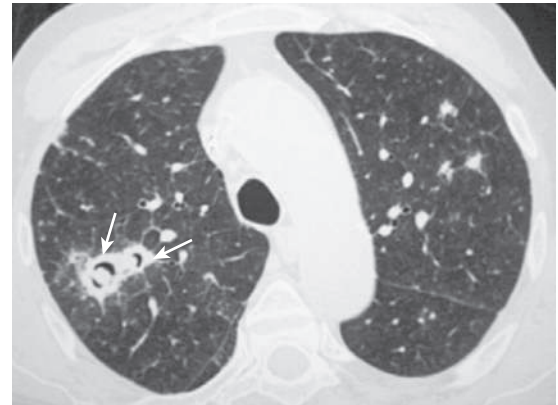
Angioinvasive aspergillosis. CT section at the level of the lower trachea shows a consolidation with an eccentric cavitation and air crescent sign (arrows). This finding in this neutropenic patient is highly diagnostic of angioinvasive aspergillosis. (From Franquet T. Nonneoplastic parenchymal lung disease. In Haaga JR, Boll DT, eds. CT and MRI of the Whole Body, 6th ed. Philadelphia: Elsevier; 2017. Fig 36.14.)
